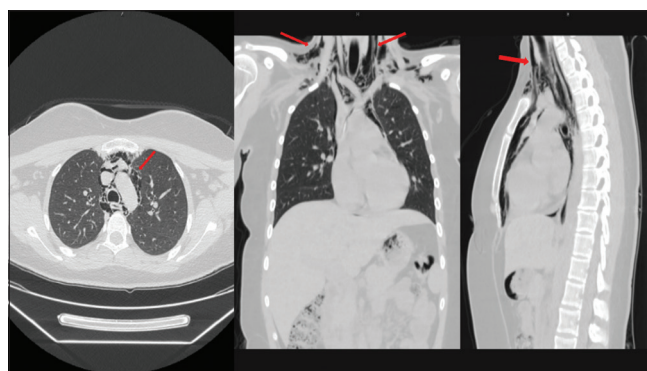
The patient's computed tomography images with transverse (left), coronal (middle), sagittal planes (right) revealing pneumomediastinum (arrows pointing the subcutaneous emphysema)
